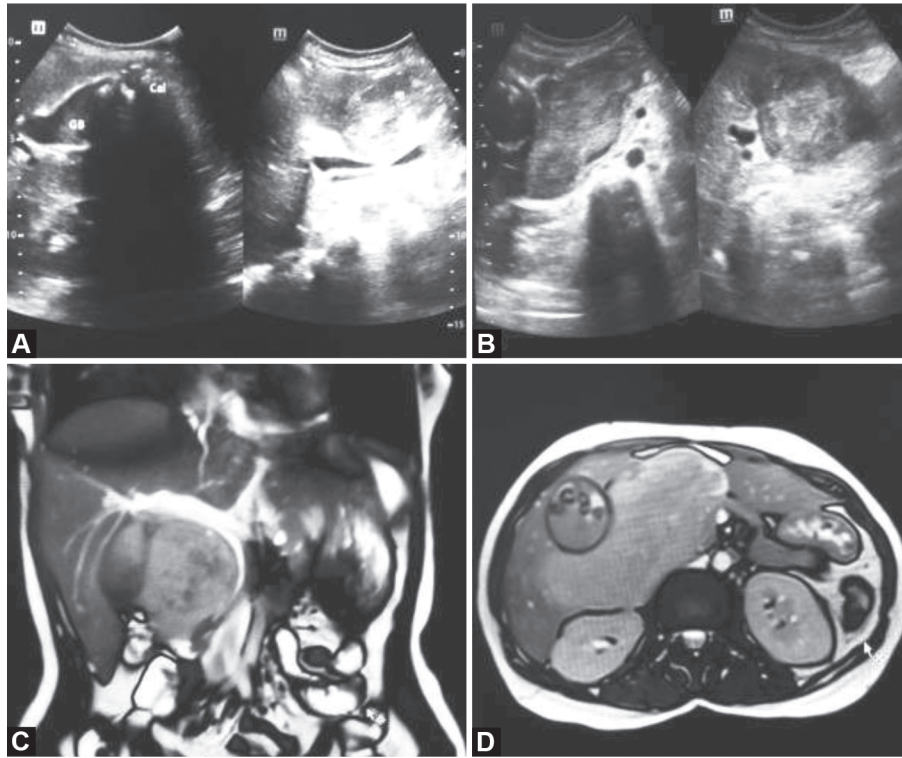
to D: Large choledochal cyst (type IVA-Todani classification): (A and B) Ultrasound showing a large fusiform type of common bile duct dilatation (>6 cm) with markedly dilated intrahepatic biliary radicles; (C and D) Magnetic resonance cholangiopancreatography showing a massively dilated fusiform type of extrahepatic common bile duct dilatation (>6 cm) with narrowing in the distal end (congenital stricture). The intrahepatic biliary radicles are also severely dilated
